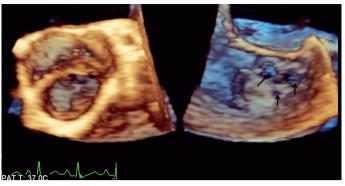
Three-dimensional transesophageal echocardiography demonstrated multiple perforations (black arrows) on the aneurysm
